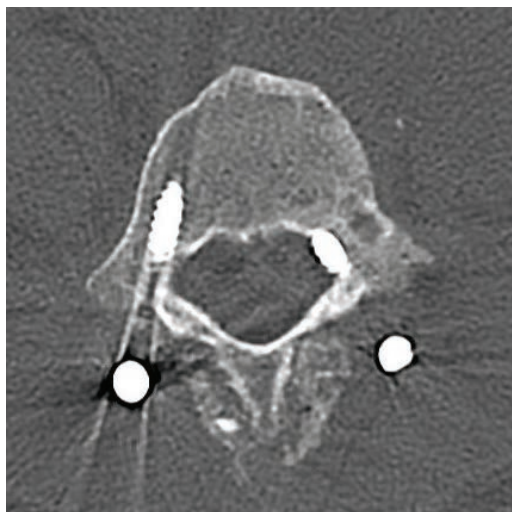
Axial cut of postoperative CT demonstrating misplaced screw at L4 pedicle on the left. Screw with noted inferior and medial breach. This is notably on the contralateral side of the patient's symptoms.
